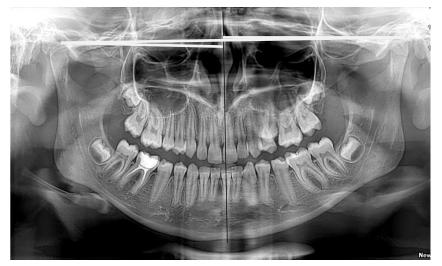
Orthopantomogram of patient K., 23 years. Diagnosis: left-side buccal cross bite.
